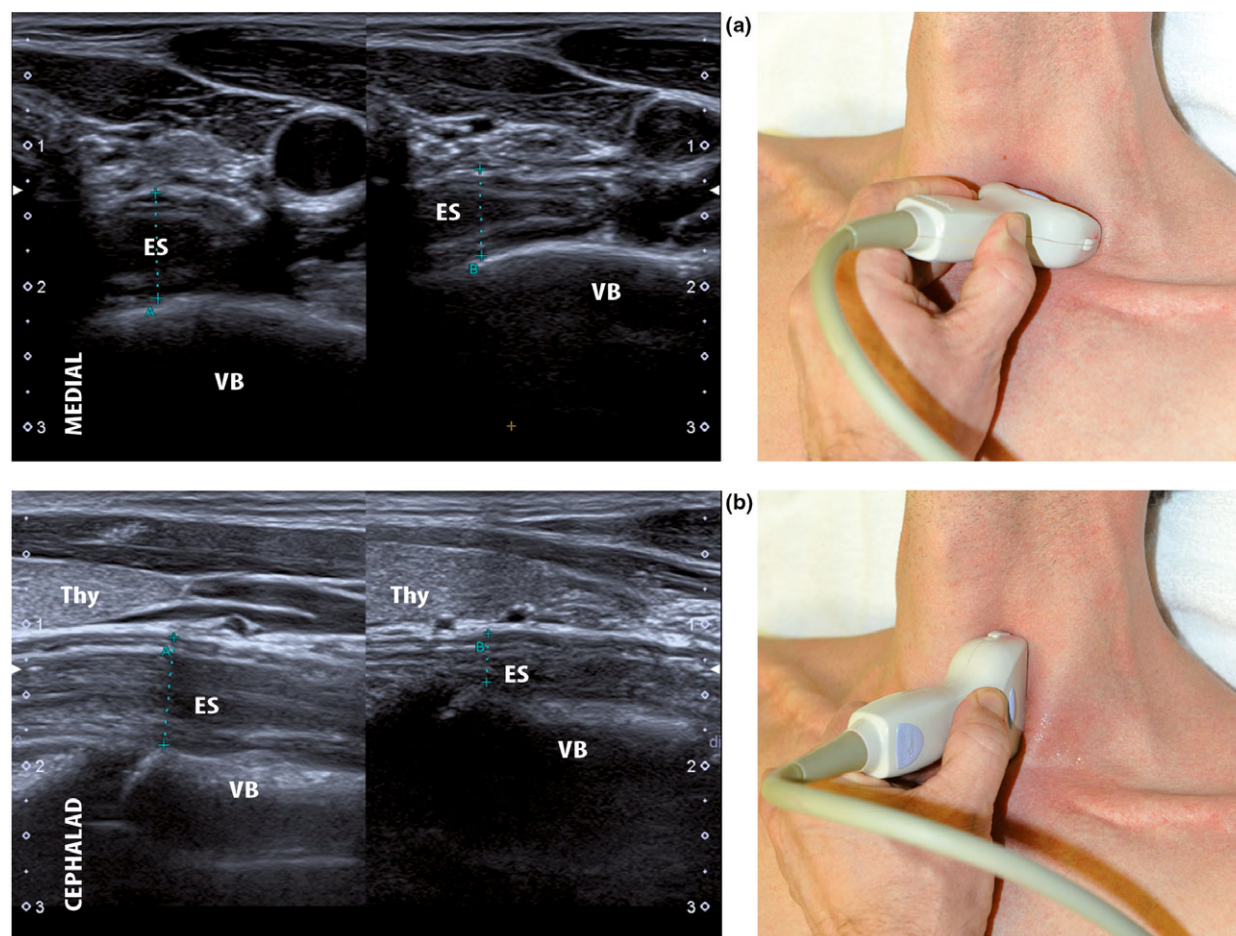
Axial (a) and sagittal (b) views of the oesophagus before and after low left paratracheal compression with an ultrasound transducer. ES, oesophagus; Thy, thyroid; VB, vertebral body.
